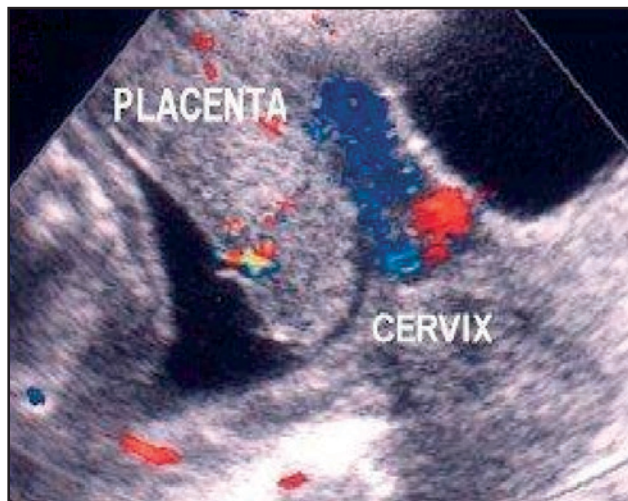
Sonogram of a total placenta previa with color Doppler. Image courtesy of Virlene Guzman, RDMS.
